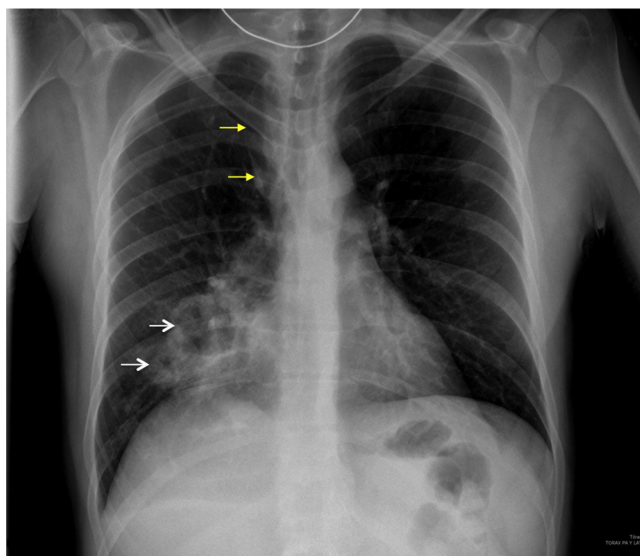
Chest X-ray showing two nodular cavitary images (white arrows) and an azygos lobe (yellow arrows).
